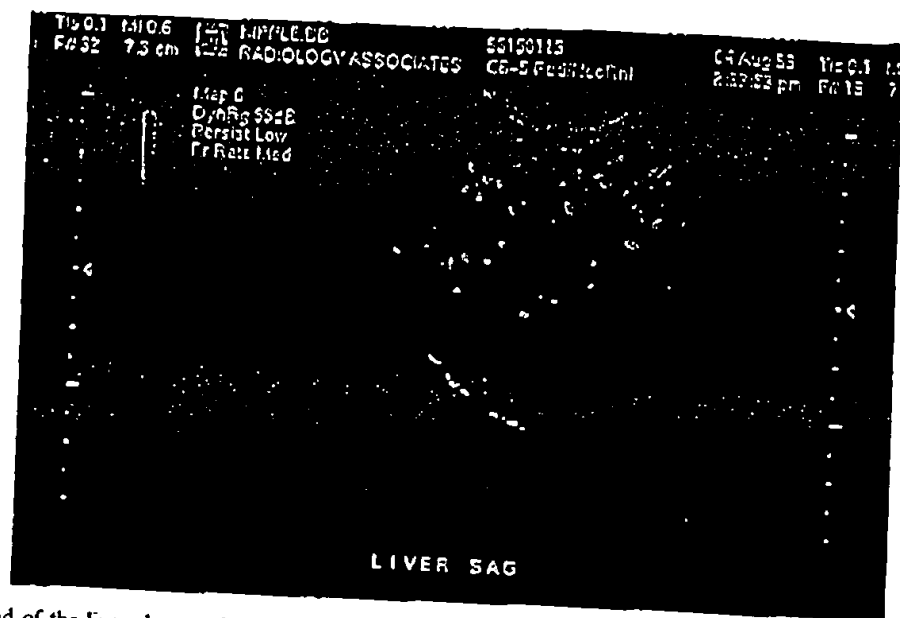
Ultrasound of the liver shows calcium lesions.
